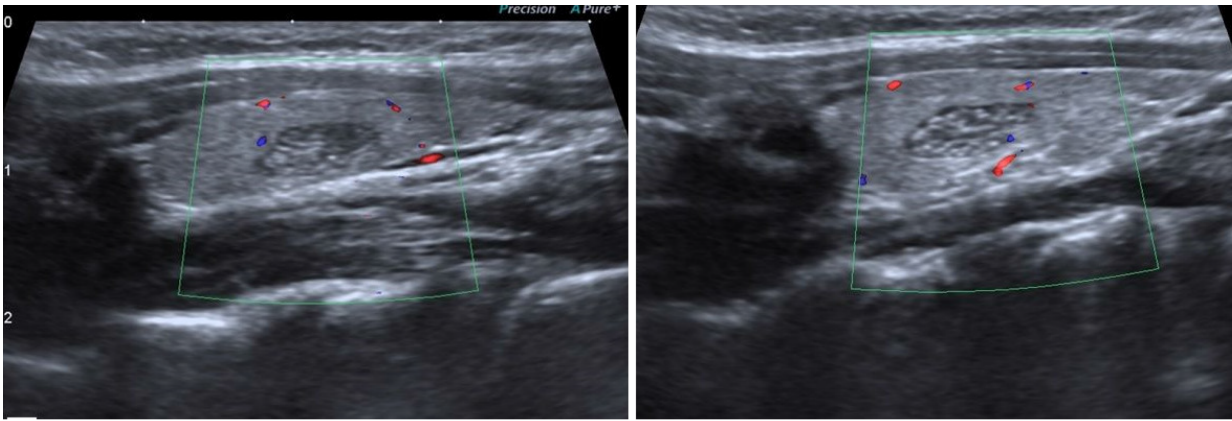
Eight-year-old asymptomatic girl. Longitudinal sonographic images obtained with 7 MHz linear transducer. Both intrathyroidal ectopic thymus cases are hypo vascular in comparison within the surrounding thyroid parenchyma.
